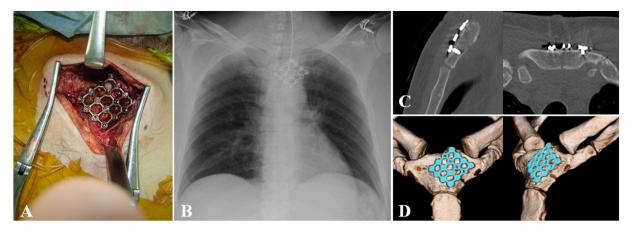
A, Intraoperative picture showing how eight locking screws were placed into the large fragment and four locking screws were placed into the small fragment. B, X-ray of mesh plate location on sternum. C and D, Computed tomography (CT) and three-dimensional CT showing post-operative findings.
